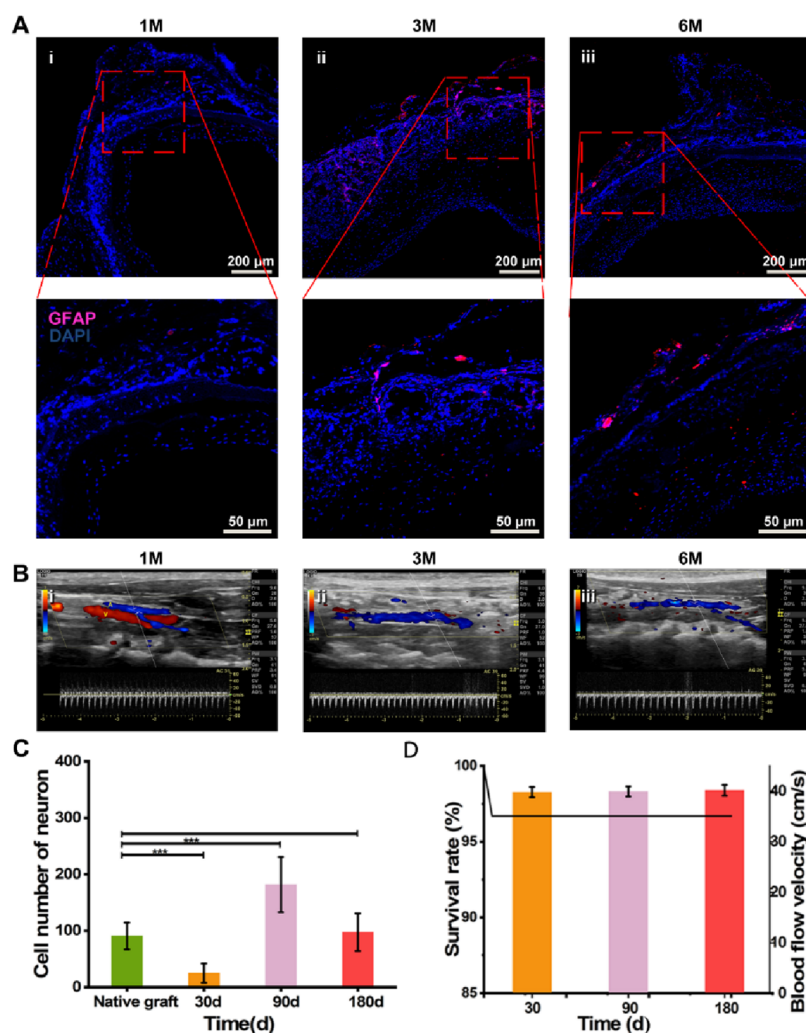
Alteration in the outer layer. A. Artificial blood vessel glial cell immunofluorescence, GFAP (glial cell marker, red), and DAPI (blue) at 1, 3, and 6 months after surgery. B. Color Doppler ultrasound of artificial blood vessels at 1, 3, and 6 months after operation; the blood circulation is unobstructed. C. Image J was employed to count the number of nerve cells. D. Blood flow velocity statistics.
